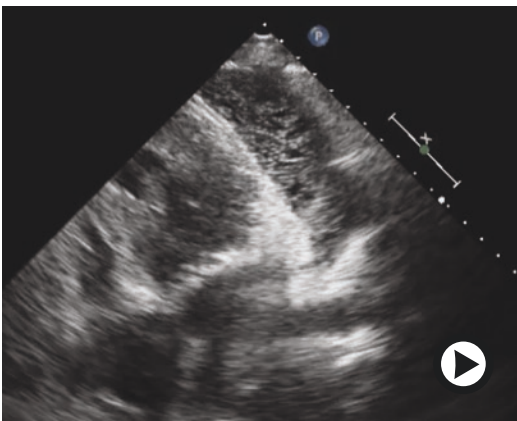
A4C view injecting agitated saline through the catheter under direct ultrasound visualization, observing for formed microbubbles in the pericardial sac. (<https://doi.org/10.1007/000-2rp>)
